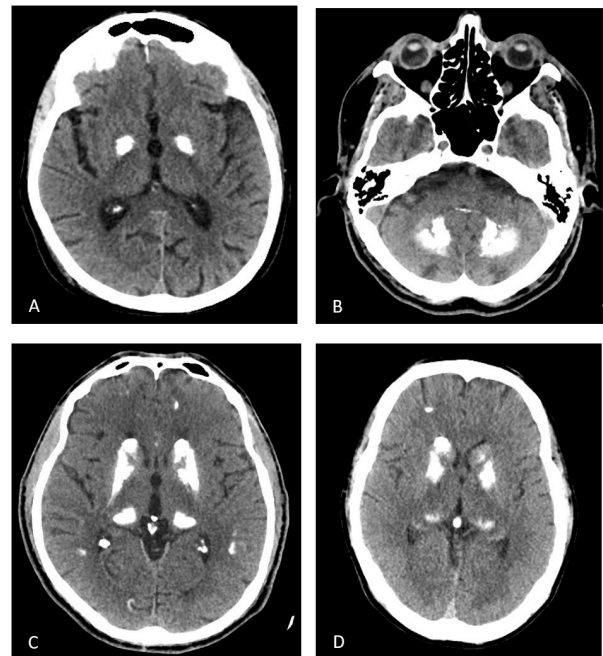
Brain computed tomography scan (CT scan) of PT7 (A), PT8 (B, C), and PT5 (D) showing bilateral symmetrical calcifications in the basal ganglia (A, C, D) and in the cerebellum (B).
